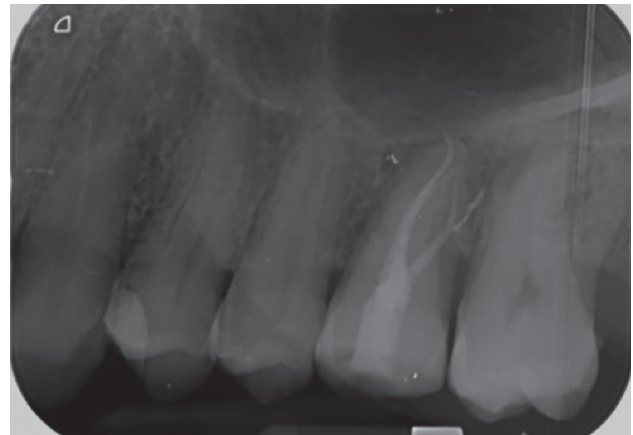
Periapical radiograph at 3 months after the autotransplant.
